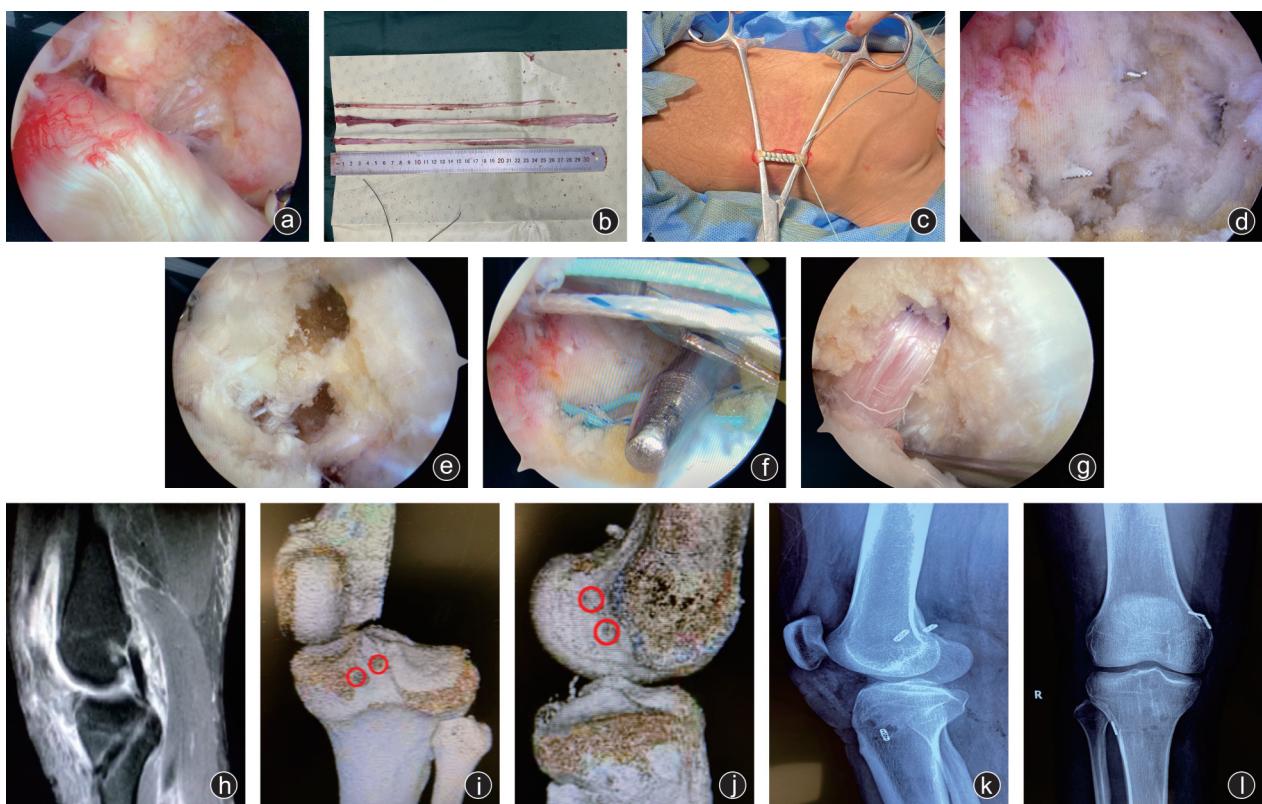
病人,男,21岁,左膝关节 PCL 损伤 a:术中镜下显示 PCL 损伤;b:术中制备移植肌腱束,从上至下依次为腓骨长肌腱、半腱肌腱、股薄肌腱;c:获取腓骨长肌腱;d:建立胫骨两骨隧道;e:术中关节镜下建立股骨两隧道;f:术中关节镜在后内侧入路观察,后外侧入路插入交换棒协助韧带通过骨隧道;g:PCL 双束双隧道重建完成;h:术后 7 d MRI 示重建韧带位置良好;i,j:术后三维 CT 可见骨道位置满意;k,l:术后 X 线片
